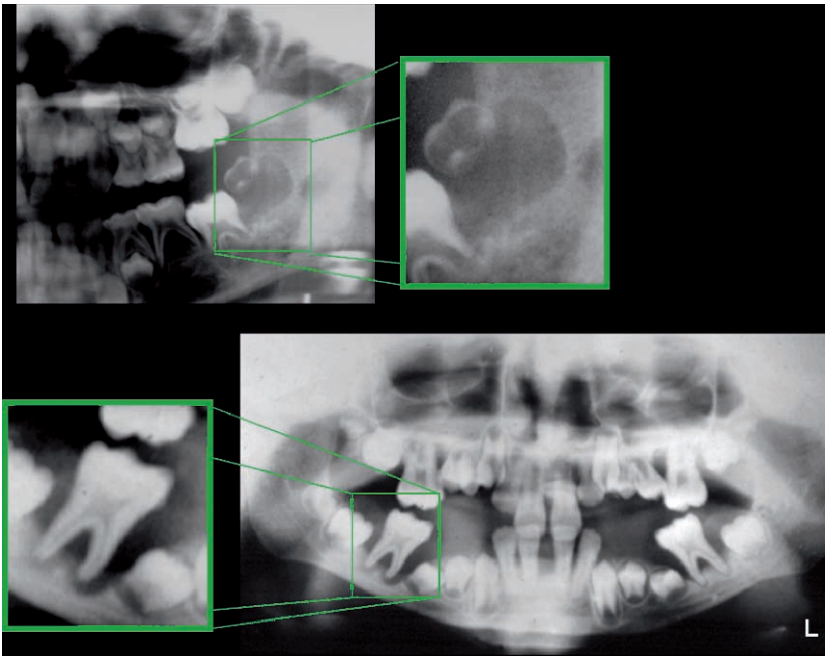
Panoramic radiographic features of two cases of acute leukemia in children: displacement of developing tooth (*upper*); causing dramatic loss of periodontal support of affected teeth (*lower*)
